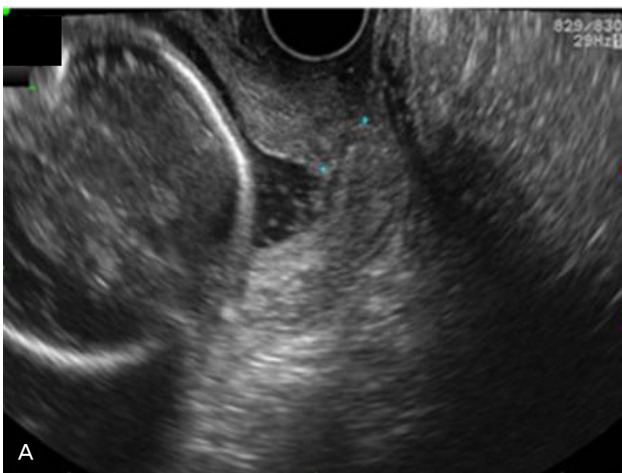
At 24th gestational week, shortening of uterine cervix with funneling was visible by transvaginal ultrasonography (A), and uterine adenomyosis with normal gestational sac was seen in transabdominal ultrasonography (B).
